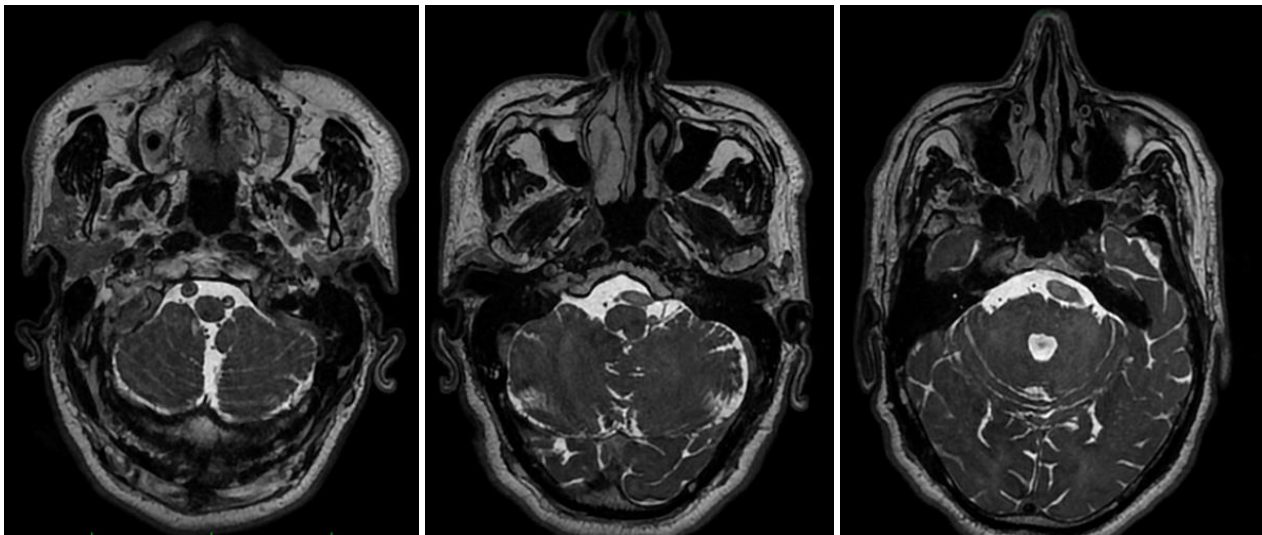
Brain MRI, T2 axial sequence: vertebral artery dilation measuring 3.9 mm on the left and 5.2 mm on the right (A); left vertebral artery crossing the cochleovestibular nerve at its REZ (B); dilated basilar trunk lateralized on the left (Smoker's Grade 2)
